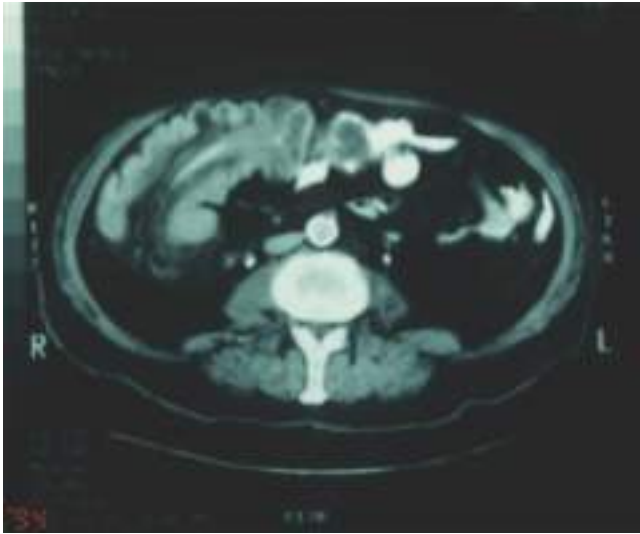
CT scan demonstrating colocolonic intussusceptions due to a lipoma.
